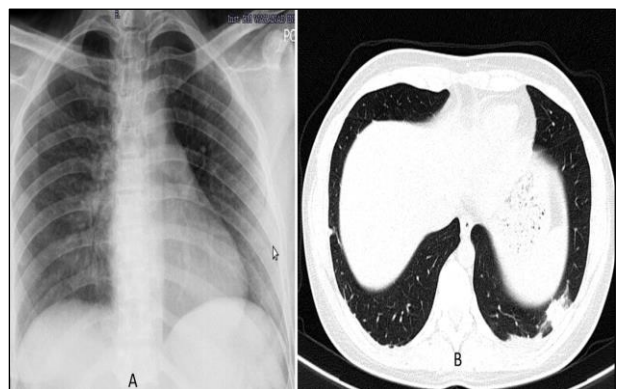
and 3B: X-ray taken on the 8th day (A) and CT thorax taken on the 14th day (B) show resolution.
